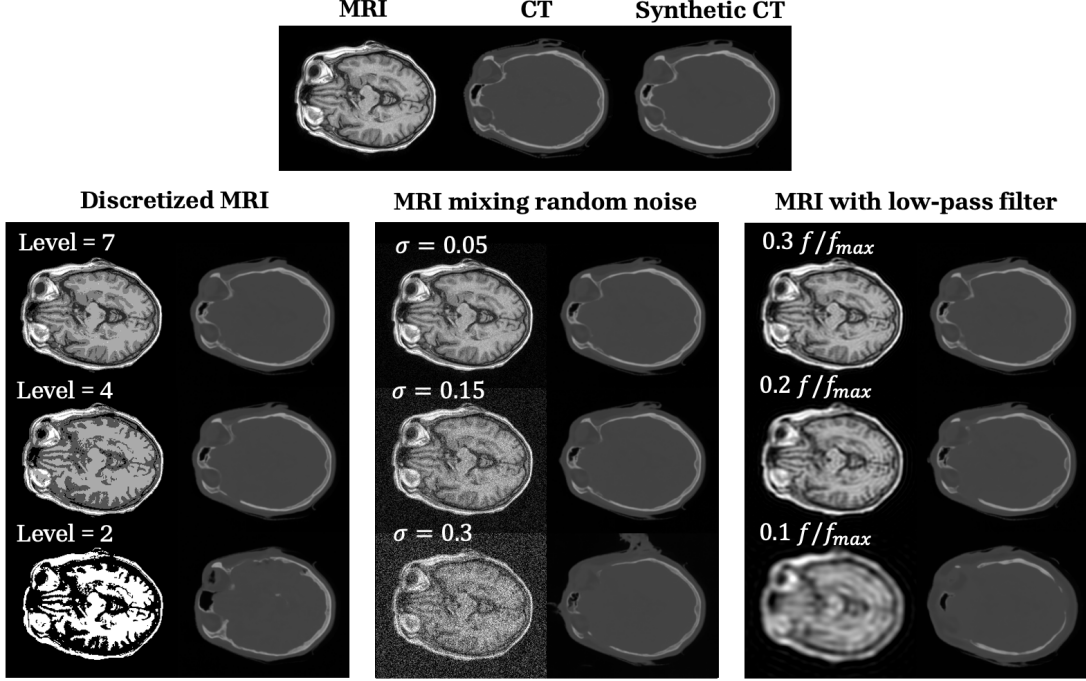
Effect of different MRI distortions on synthetic CT reconstruction: a) intensity discretization, b) mixing random noise, and c) low-pass filtering.
